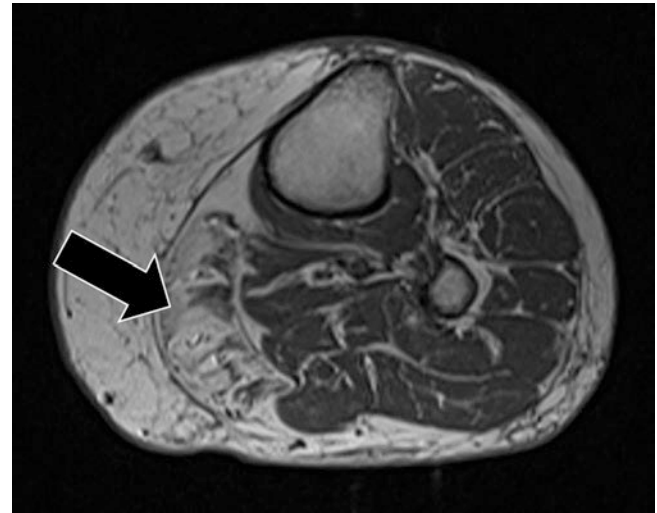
Axial T1 MR image of the left lower leg in an 82-year-old male demonstrates profound isolated fatty infiltration of the medial head of the gastrocnemius muscle (black arrow). This pattern when symmetric is in keeping with chronic changes of inclusion body myositis
